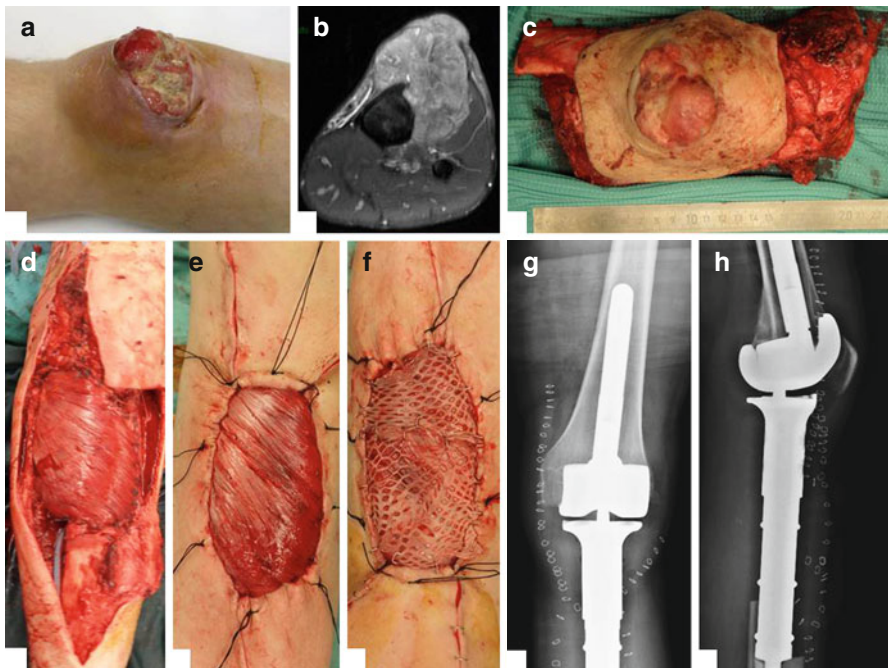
The figure showing the ulcerative pleomorphic sarcoma of the knee (a) with its MRI imaging (b). The patient underwent an intra-articular resection (c) and reconstruction with tibial and femoral mega-prosthesis and gemellus muscle flap with skin graft (d–f). Anteroposterior and latero-lateral postoperative X-ray of the leg (g, h)
